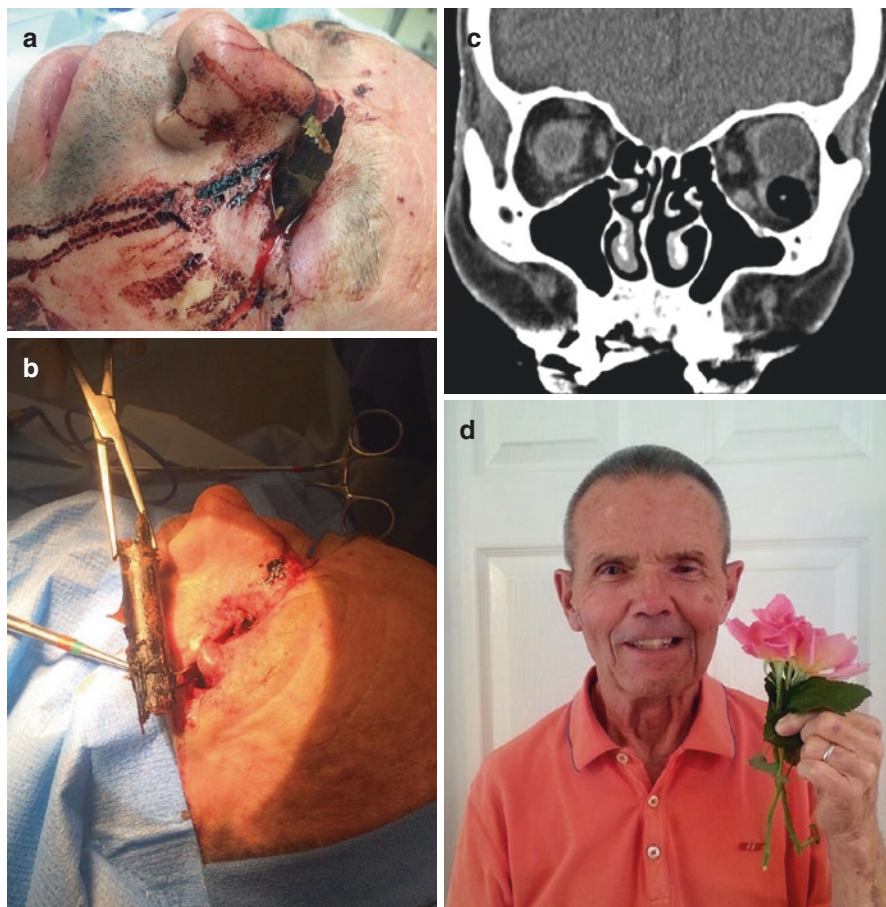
(a) External intraoperative photo of patient who sustained a fall onto a rosebush. (b) External intraoperative photo of wooden foreign body once removed after orbitotomy. (c) Coronal CT scan of the same patient with wooden foreign body visualized along inferotemporal orbit. (d) External photograph of the same patient 2 years after injury with flowers from the same rosebush that caused his orbital injury
